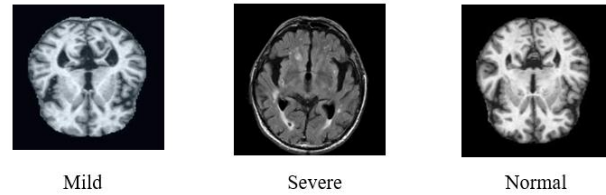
Sample MRI brain images taken from the dataset
